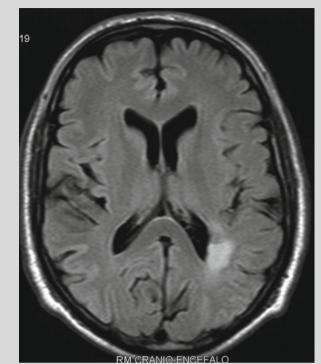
DWI MR showing subcortical left parietal infarct
